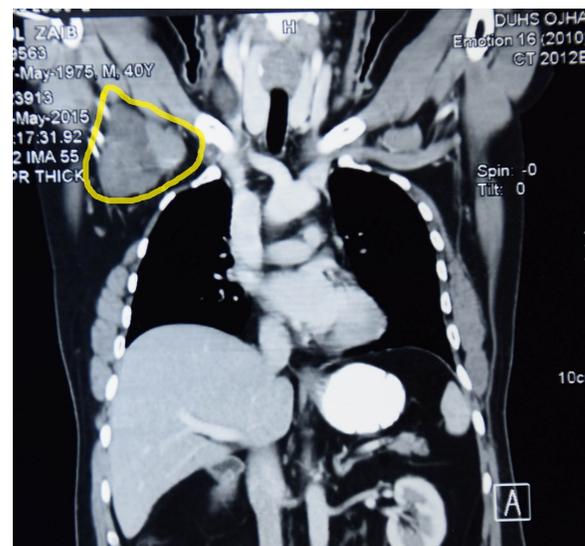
Computed Tomography scan of the chest with contrast showing the lesion (coronal section)
